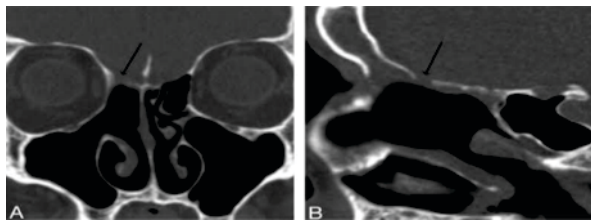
CT A) coronal & B) Sagittal section showing defect at cribriform plate
